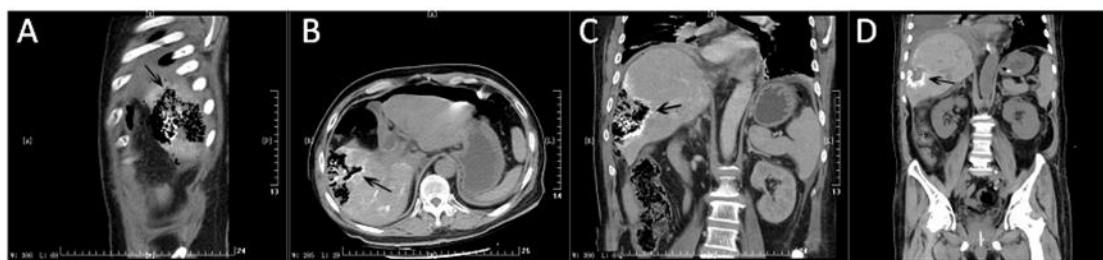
CT found an 83×48 mm area of low attenuation in the posterior segment of the right hepatic lobe with gas formation. No sign of enlargement or gas containing in bile duct; D) after 3 weeks, CT scan showed abscess in abdominal cavity was formed and liver rupture turn smaller.
